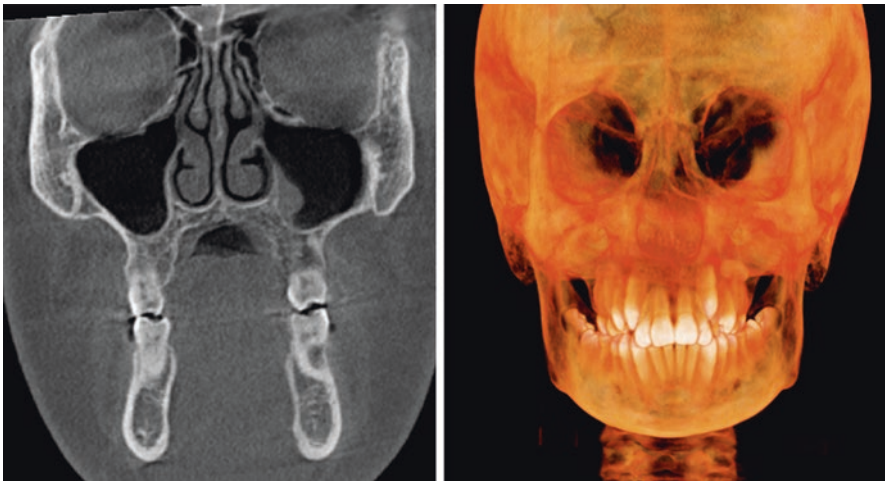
Coronal and 3D reformation of CBCT data shows the narrow transverse dimension of the nasal cavity and the arches. The floor of the nasal cavity is the hard palate, and changes in the transverse dimension of the maxilla often affect the dimensions of the nasal cavity
